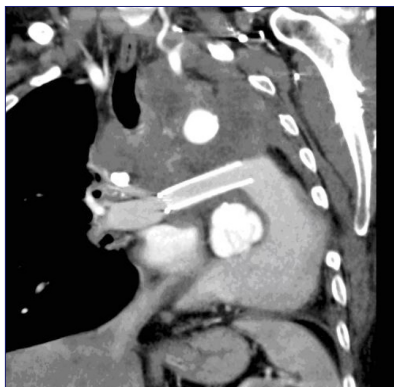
Arterial phase CT Thorax with coronal reconstruction demonstrating Pulmonary Artery Stent.
